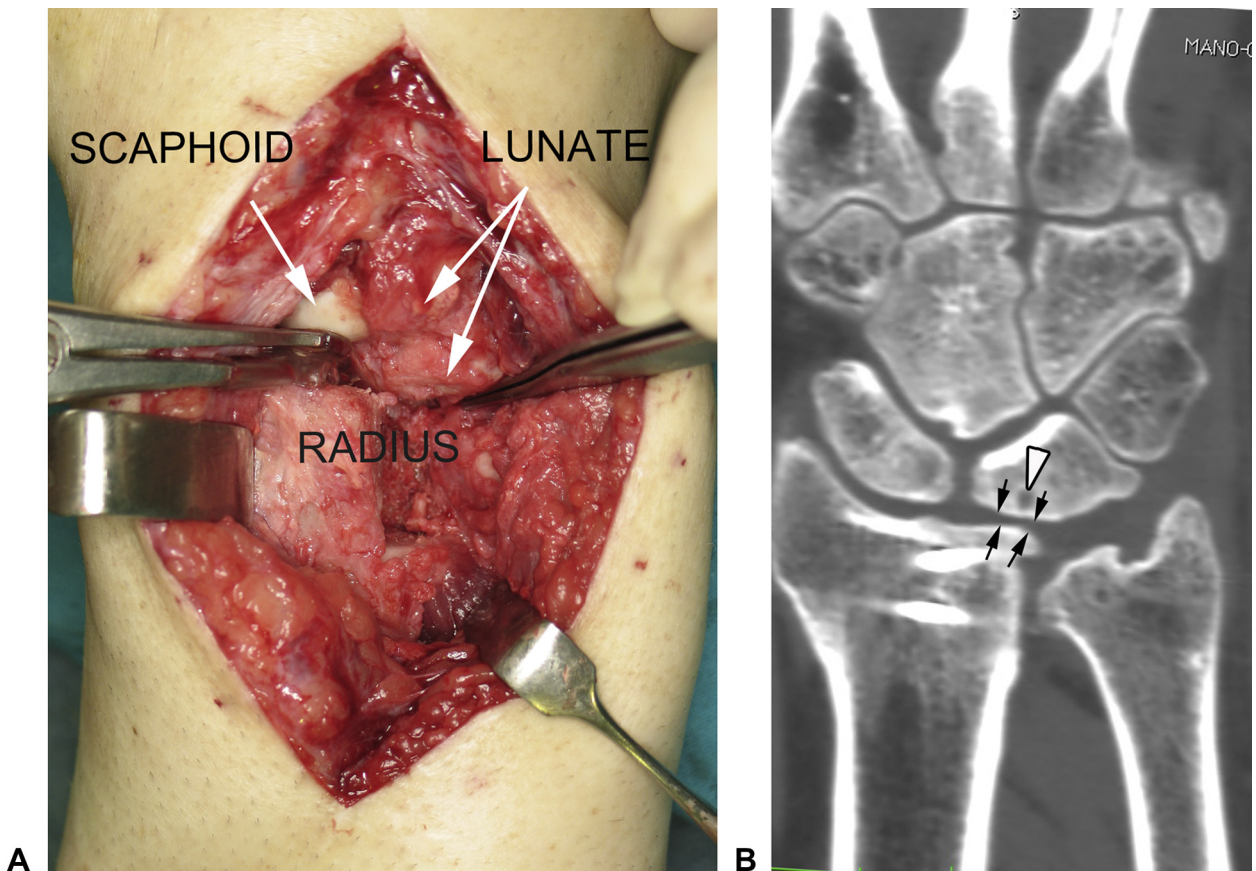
A, B Patient 3: A The cartilage on the proximal lunate has been replaced by scar tissue (compared to the healthy scaphoid cartilage). B Despite this, an acceptable result was obtained despite some narrowing (black arrows) and cysts (white arrowhead) evident on the 7-year follow-up CT scan.
